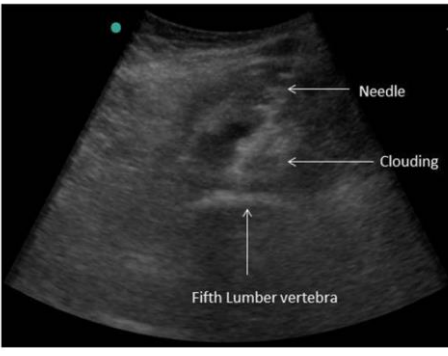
Transverse ultrasound image of the tip of needle positioned at the most-anterior point of the fifth lumbar vertebral body and drug spread in the mid-line in the form of cloud in front of the lumbar vertebra.
